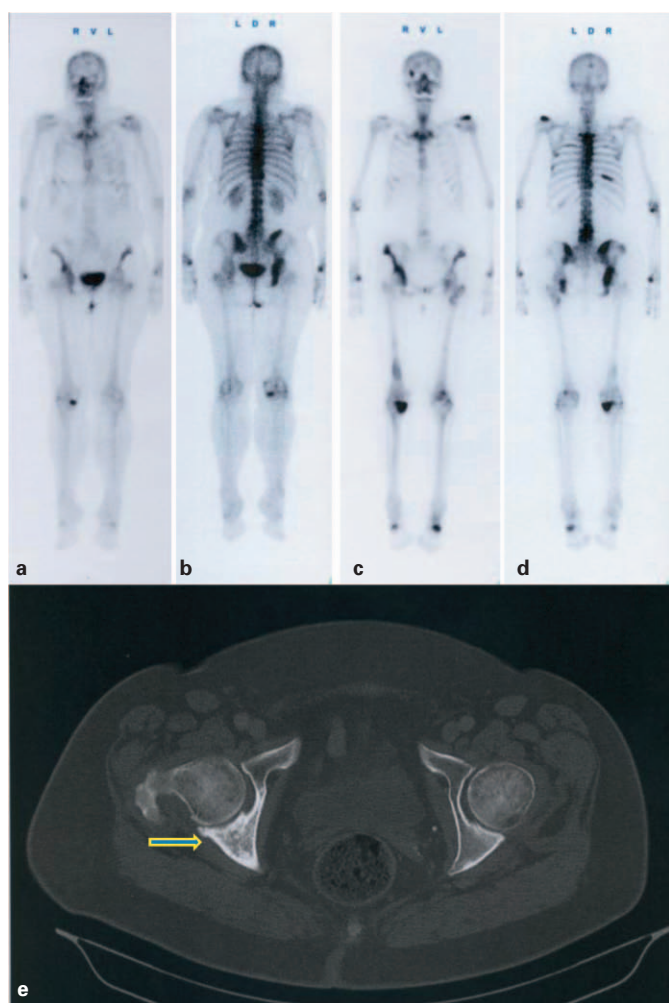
A 68-year-old female patient with breast cancer. Whole-body bone scan 3 h after intravenous injection of 656 MBq $^{99\text{m}}\text{Tc}$ -DPD, in anterior (a) and posterior view (b). Last post-therapy whole-body scan (c, d) 23 h after intravenous injection of 3.2 GBq ^{153}Sm -EDTMP. Mild progressive disease after a cumulative activity of 17.0 GBq ^{153}Sm -EDTMP; cancer antigen (Ca) 15-3 was increased from 65.5 U/ml (staging scan) to 175 U/ml 15 months later. (e) Computed tomography of the pelvis after the third ^{153}Sm -EDTMP and continuous bisphosphonate therapy, showing calcification of a large, mainly lytic lesion of the pelvis (arrow).
